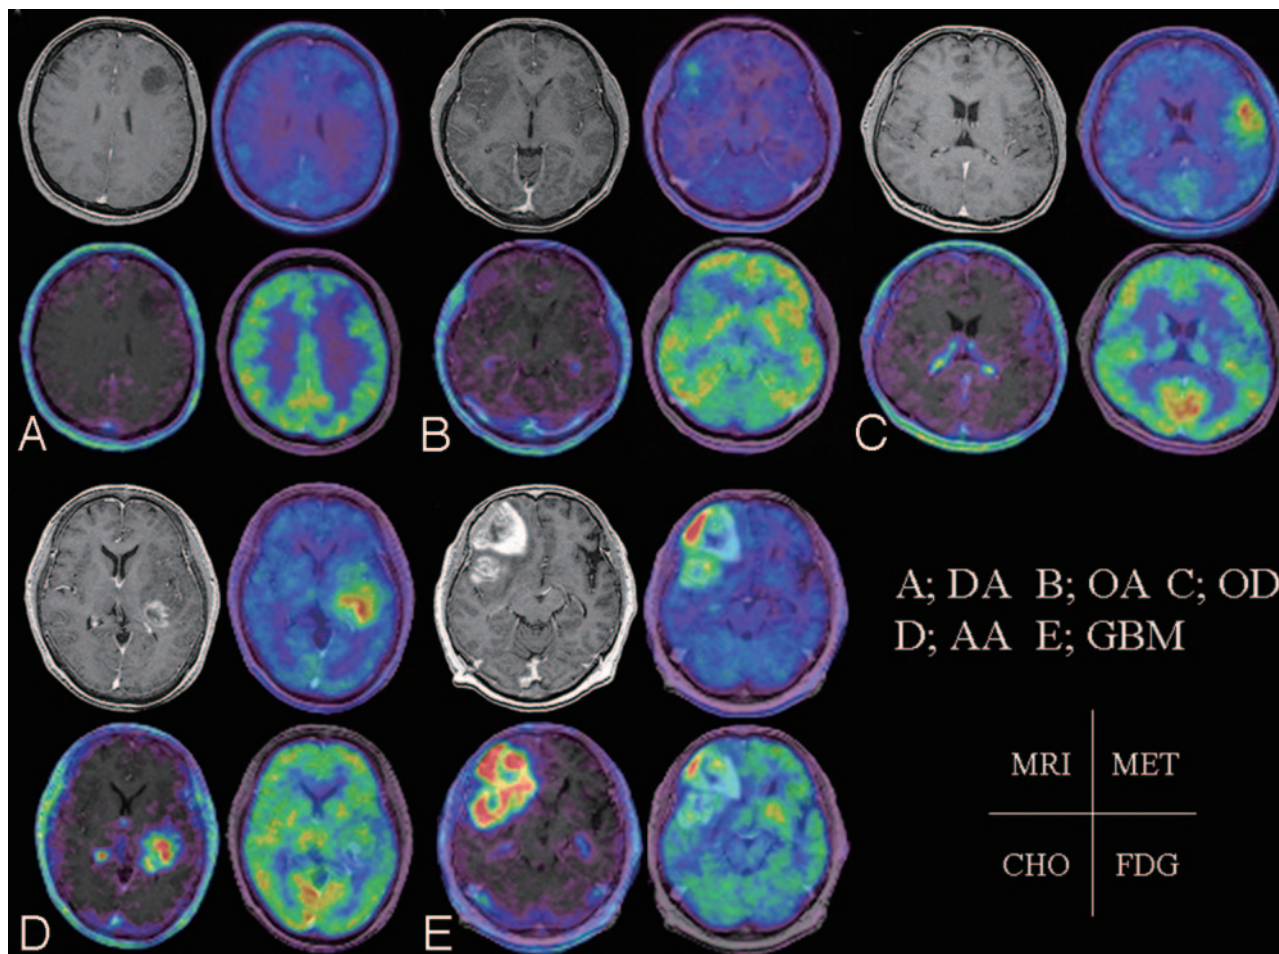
Left top, Contrast-enhanced, T1-weighted image. Right top, MET PET is superimposed on MR imaging. Left bottom, CHO PET is superimposed on MR imaging. Right bottom, FDG PET is superimposed on MR imaging. A, A 32-year-old woman presented with diffuse astrocytoma. MET T/N ratio = 1.72, CHO T/N ratio = 1.38, and FDG T/N ratio = 0.66. B, A 23-year-old woman presented with oligoastrocytoma. MET T/N ratio = 2.76, CHO T/N ratio = 1.82, and FDG T/N ratio = 0.92. C, A 44-year-old man presented with oligodendroglioma. MET T/N ratio = 3.71, CHO T/N ratio = 2.74, and FDG T/N ratio = 1.07. D, A 62-year-old woman presented with anaplastic astrocytoma. MET T/N ratio = 4.26, CHO T/N ratio = 10.17, and FDG T/N ratio = 1.24. E, A 68-year-old man presented with glioblastoma multiforme. MET T/N ratio = 6.85, CHO T/N ratio = 33.38, and FDG T/N ratio = 2.55.
